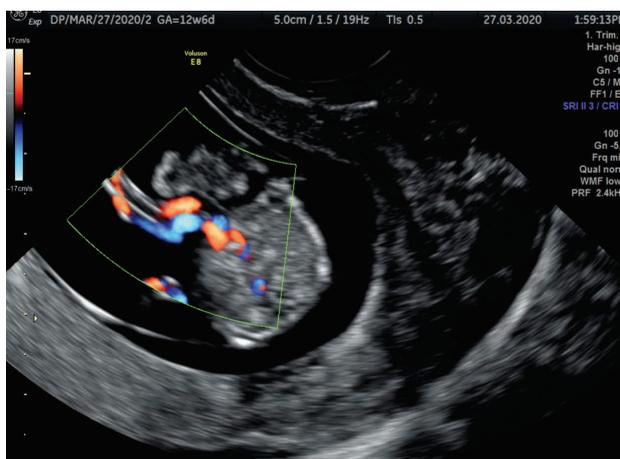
2D color Doppler Transversal abdominal section: on the right side of the umbilical cord insertion and cranial of it the gut is visible floating in amniotic fluid, uncovered by the peritoneum and non-included in the umbilical cord insertion as a differential diagnosis with omphalocele
